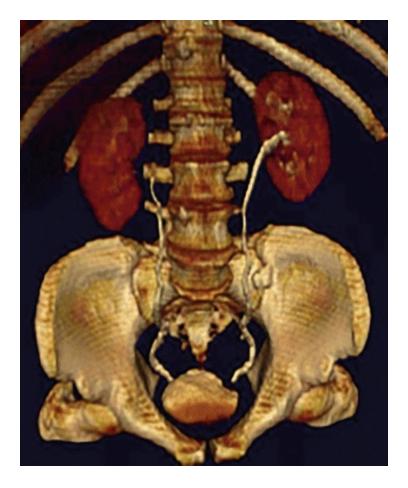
CT urography with 3D reconstructions demonstrates a distal urothelial carcinoma at the left ureterovesicle junction with a mass-like filling defect
